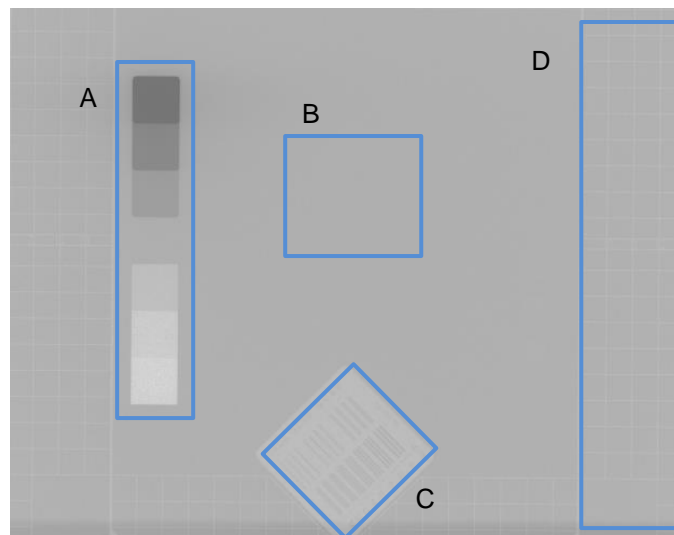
X-ray test pattern with different quality domains; A. contrast; B. homogeneity; C. spatial resolution; D. geometrical behavior
